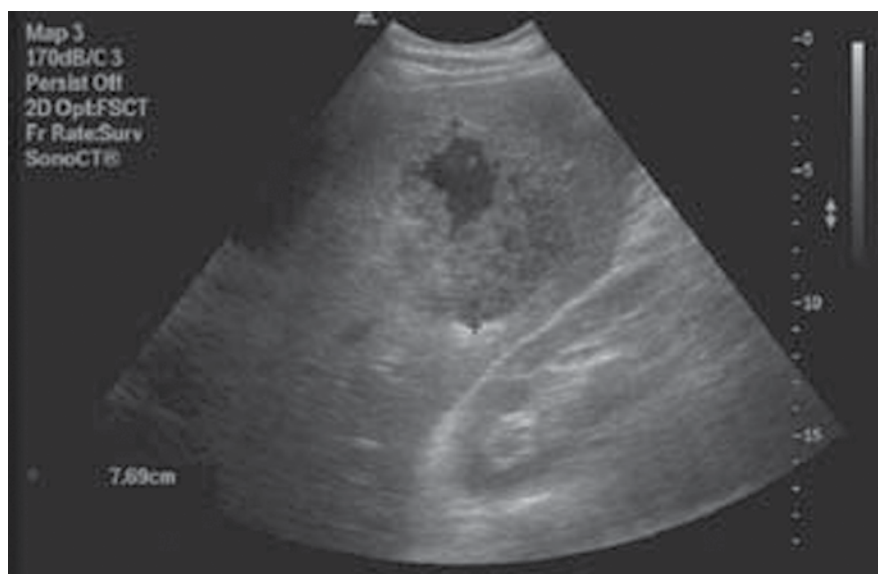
Abdominal ultrasound scan showing liver lesion.
